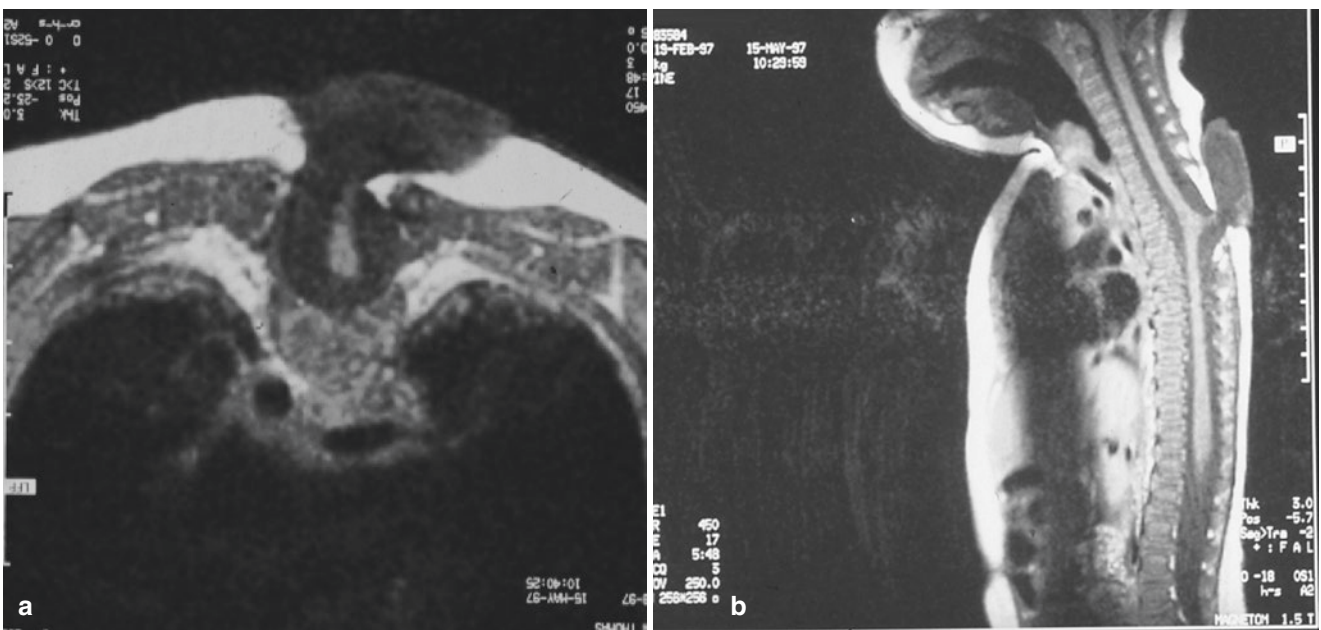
(a) Cross-sectional view of a thoracic meningomyelocele showing the body of the vertebra and the laminae splayed out with the myelomeningocele protruding out of the back. (b) An MRI scan showing a lateral view of a thoracic myelomeningocele. Note how the spinal cord is tethered at the lesion
